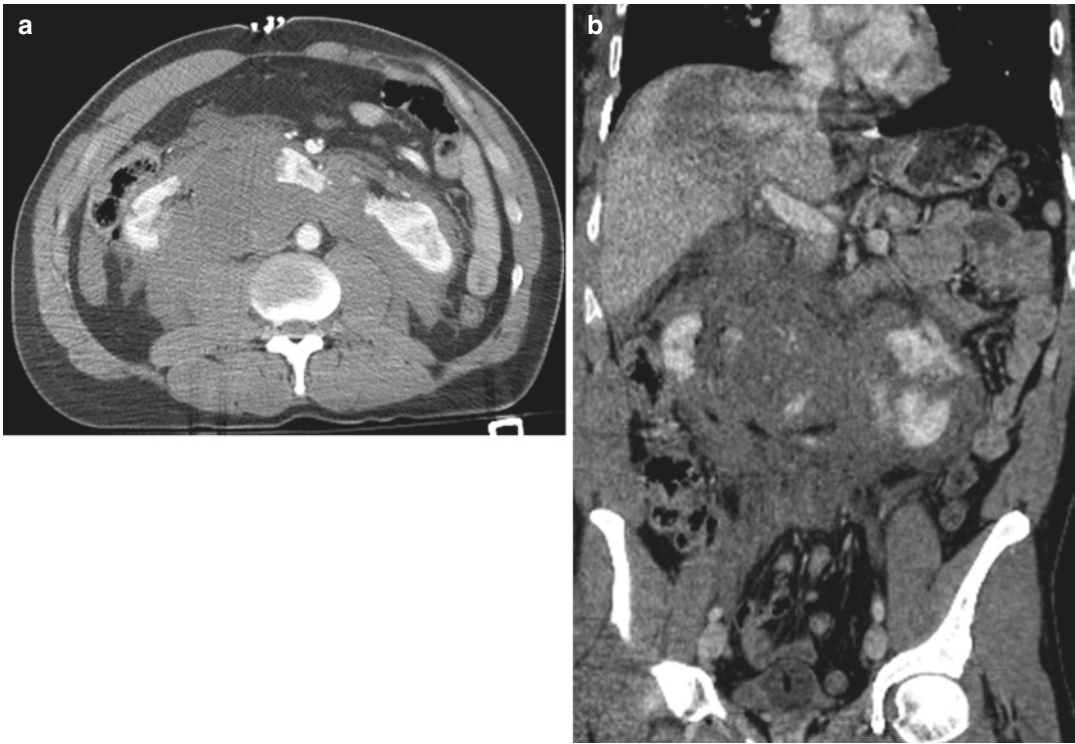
Contrast-enhanced CT, axial scan (a), and coronal reconstruction (b) show a complete fracture of the middle part of a horseshoe kidney, with huge retroperitoneal hematoma
